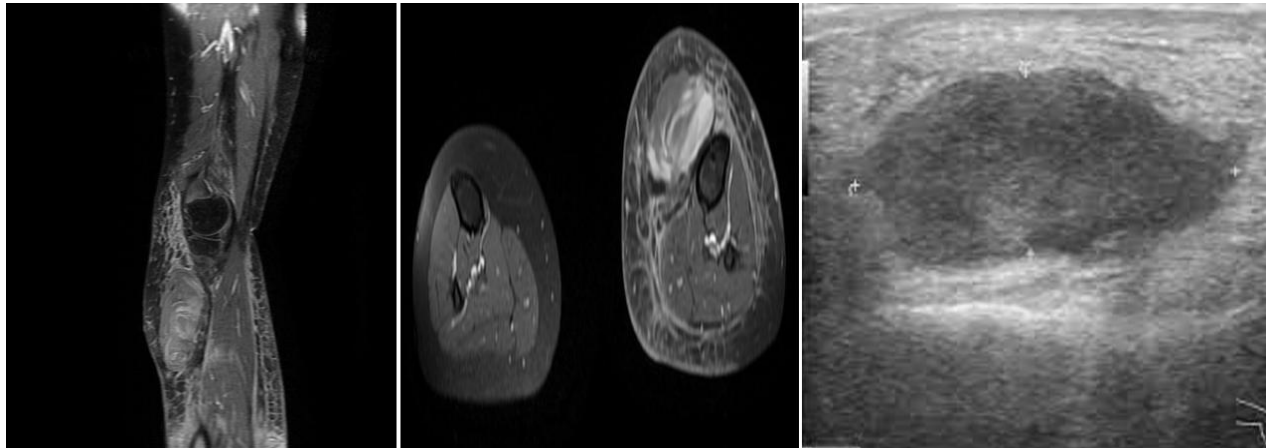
Showing an ovoid hypoechoic lesion on ultrasound scanning with profuse surrounding hyperechoic inflammatory fatty adipose soft tissue planes. MRI shows variable layering high signal pattern of this hematoma with concentric pattern on all available T2 WI series with profuse surrounding adipose soft tissue edematous changes.
